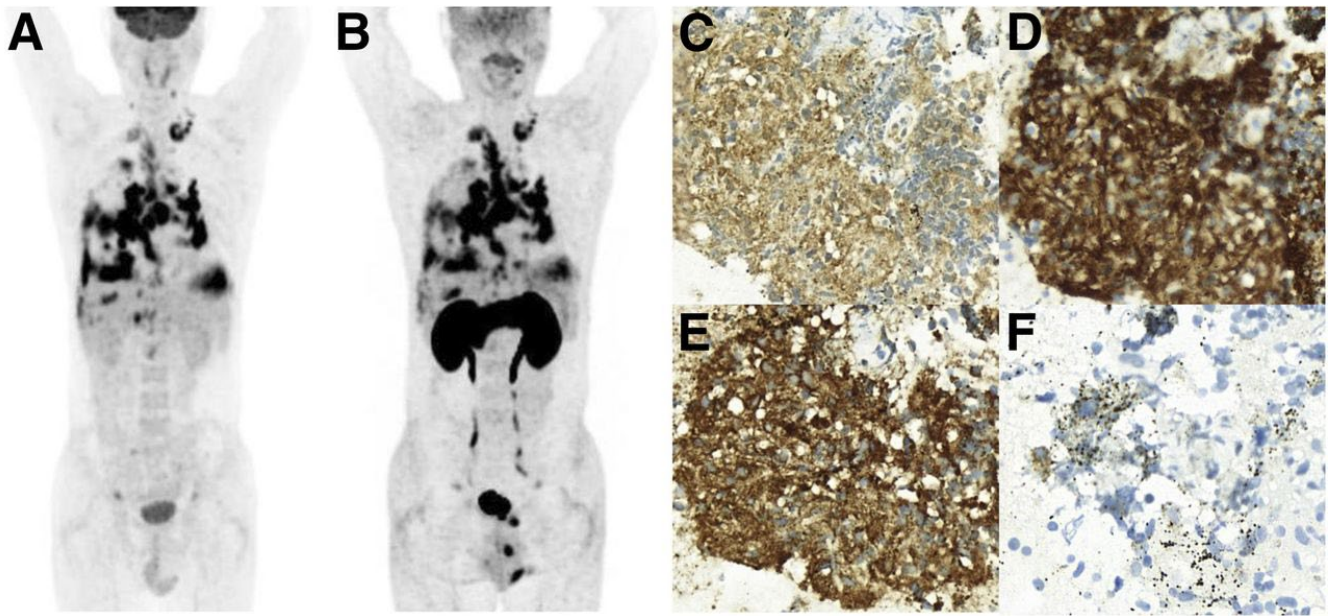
53 year old man with sarcoidosis: 18F-FDG (A) and 18F-FSPG (B) present similar major uptake involving pleura, supraclavicular lymph nodes, and thoracic lymph nodes. Sun Young Chae et al. J Nucl Med 2016;57:67-69.
